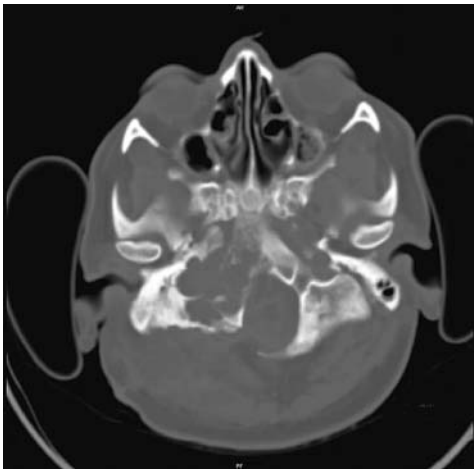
Pre-operative CT scan (bone window) with destruction of the posterior fossa skull base (occipital, petrous and clivus)
